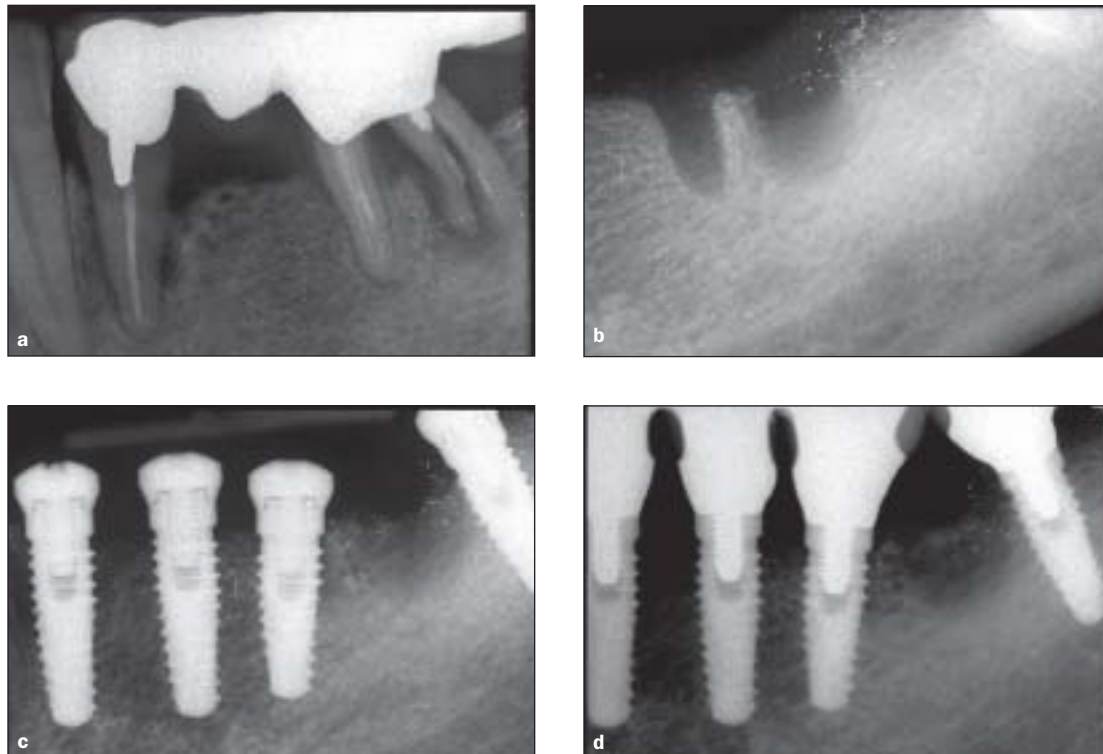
Radiographs of a patient treated with 4 NT implants placed in the posterior mandible in fresh extraction sockets. (a) An FPD supported by teeth with a hopeless prognosis. (b) After extraction. (c) Four 4 × 13 mm NT implants placed immediately after tooth extraction. (d) Implants restored with the definitive prosthesis; radiograph taken 6 months after loading.
